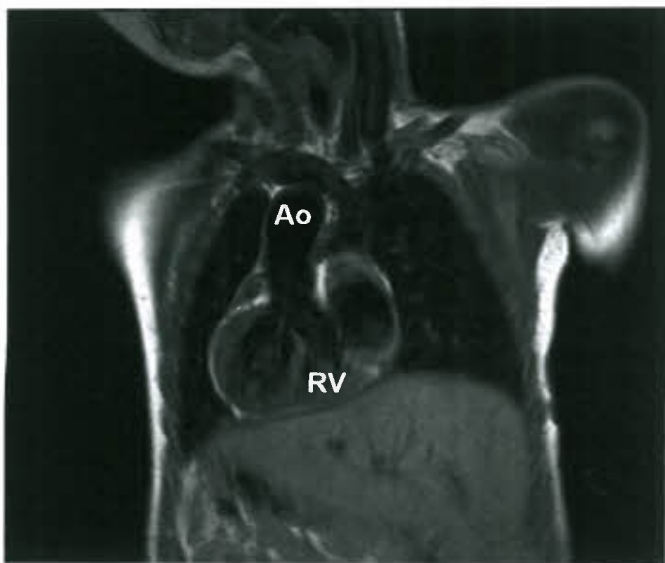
Frontal cut of T1-weighted MRI in congenitally corrected transposition of the great arteries with dextroposition, ventricular septal defect, and pulmonary atresia. (Ao, aorta; RV, right ventricle.)
